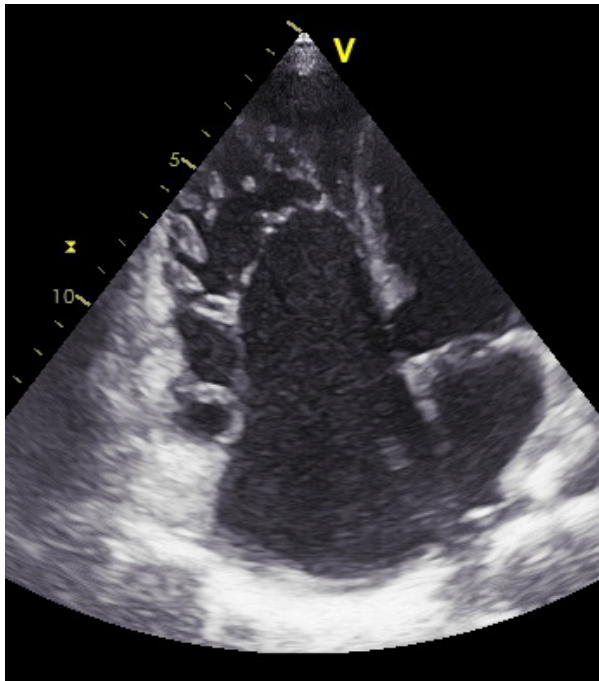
Doppler color echocardiogram. Apical 4-chamber view shows the typical apical displacement of the tricuspid valve (severe Ebstein's malformation).
